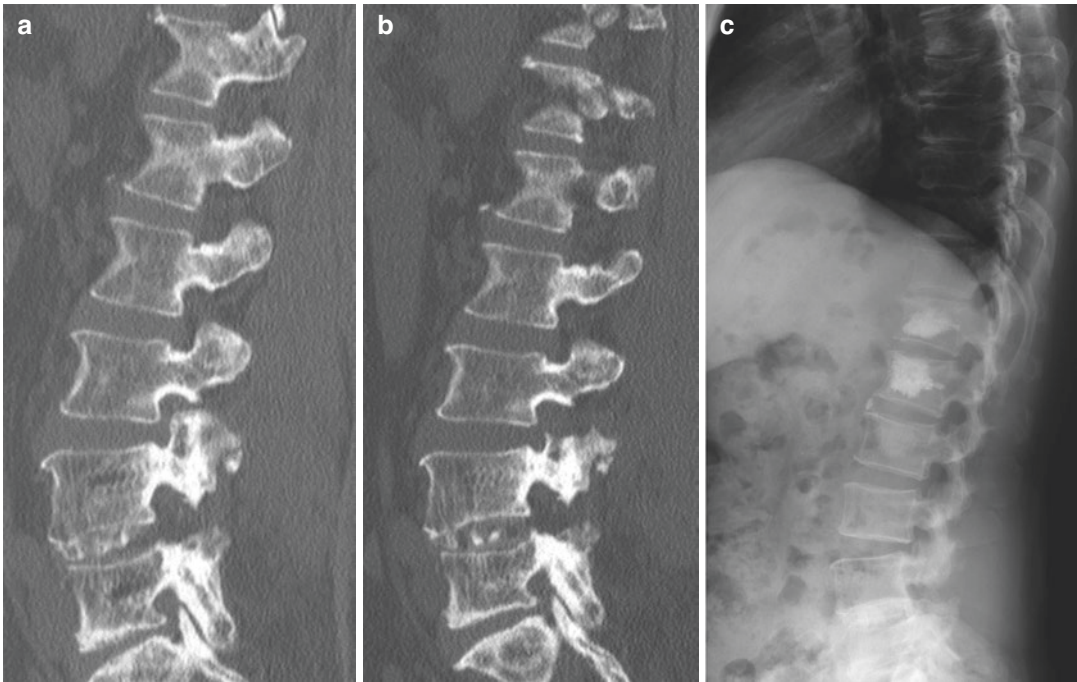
A 56-year-old woman underwent O-arm navigation-guided left L3-4 TELF. (a) The preoperative CT image. (b) The postoperative CT image. (c) Postoperative lateral radiograph showed no iatrogenic spondylolisthesis
